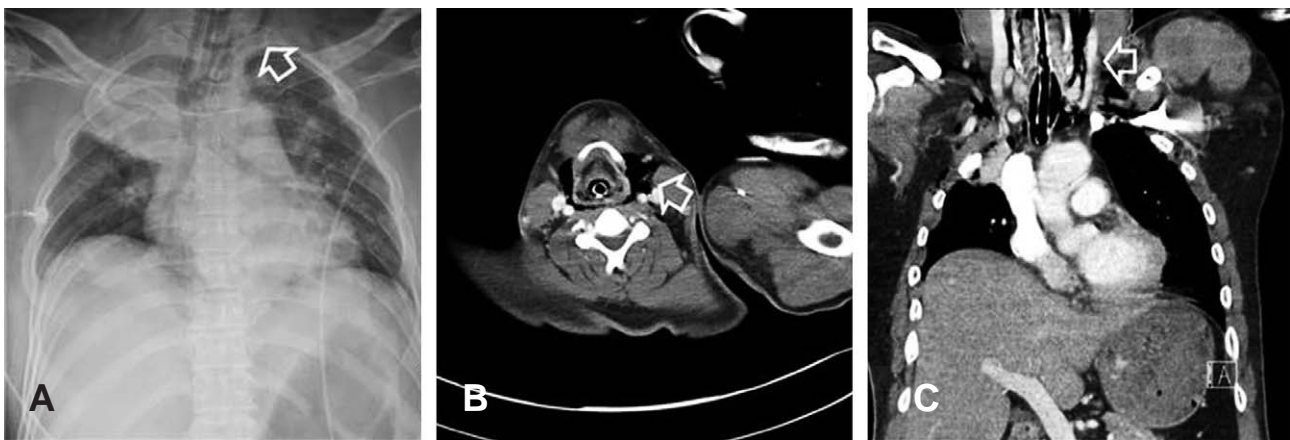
Chest X-ray and chest computed tomography shows extensive emphysema (arrow) from the deep neck to the chest wall. The massive air are mainly present in the deep neck (A, B, C).
